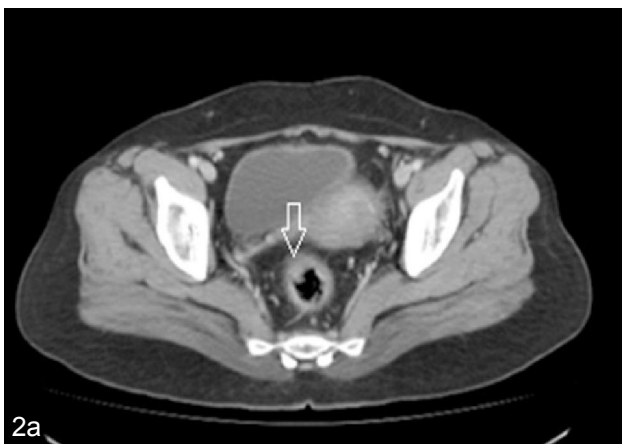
Contrast enhanced CT scan showing lesion in anterior wall (thin arrow) and right lateral wall (thick arrow) of the rectum
